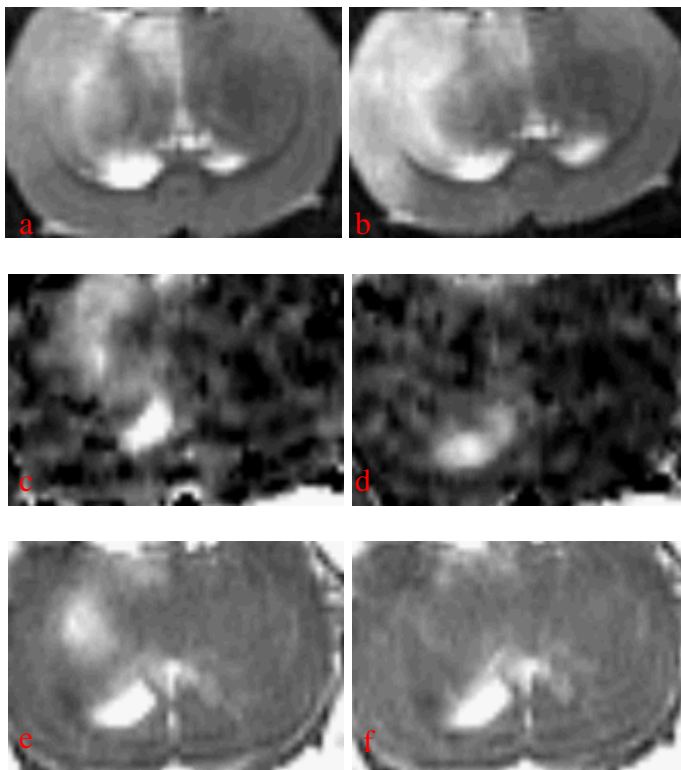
T2-weighted images, a: 1hr and b: 24 hr after reperfusion; permeability maps, c: 1hr and d: 24hr after reperfusion; T1-weighted images, e: 1hr and f: 24hr after reperfusion.
